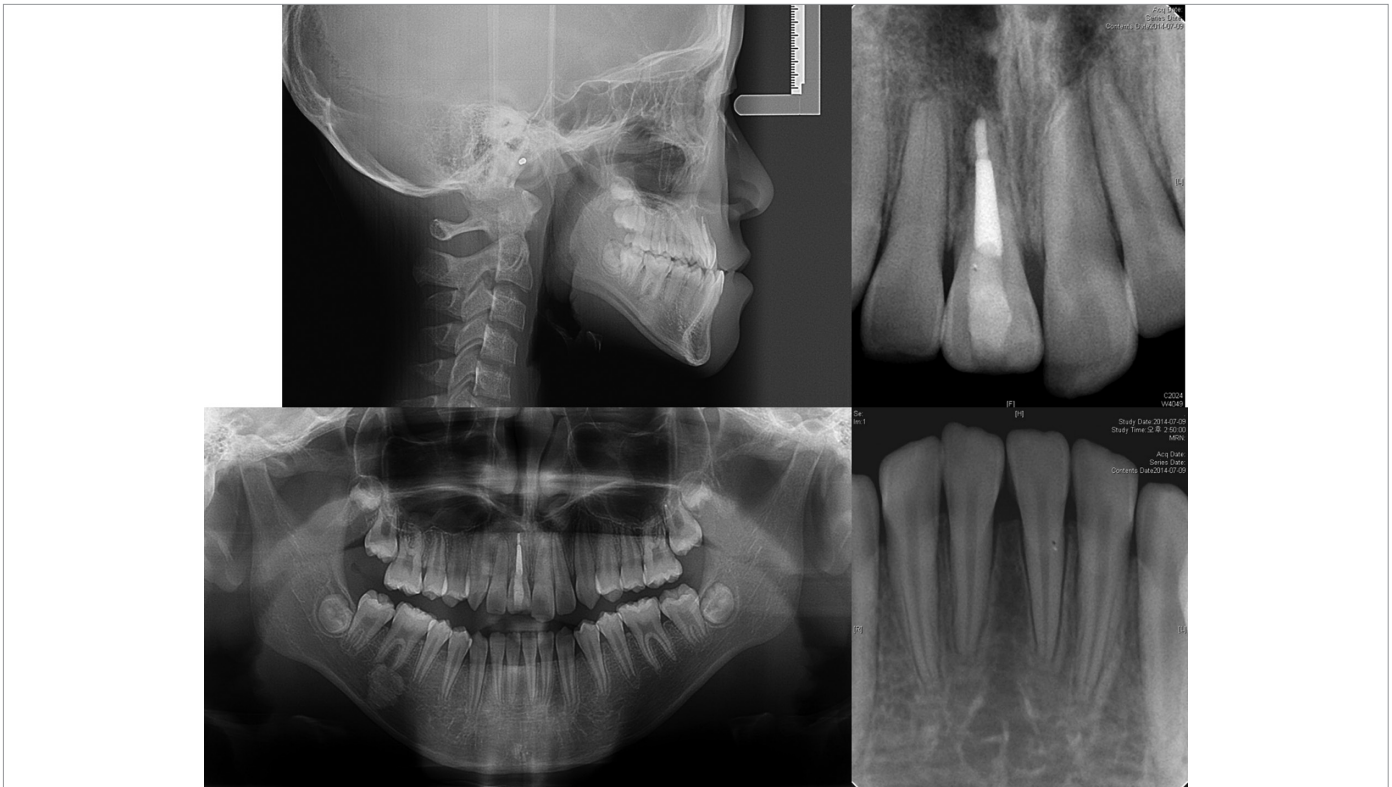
Radiographs from the patient's initial diagnostic evaluation
